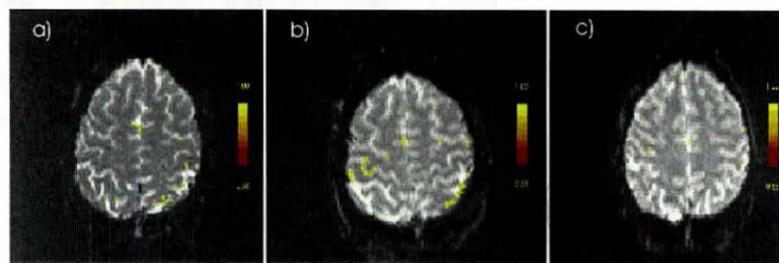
Cortical activation within the secondary somatosensory cortex SII a) prior to DWI, b) immediately after DWI and c) one week after DWI. The baseline study shows weak SII activation ipsilaterally to the tapping left hand, immediately after DWI, two sharply delineated SII activation foci can be seen, which disappear again one week after DWI.
